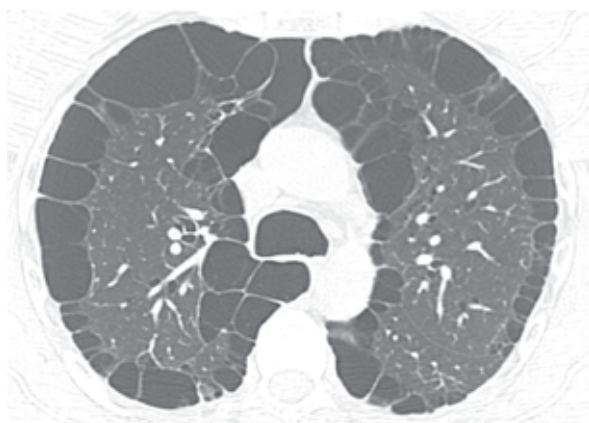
An axial CT scan at the level of the upper lobes shows a single layer of subpleural cystic spaces consistent with paraseptal emphysema.
